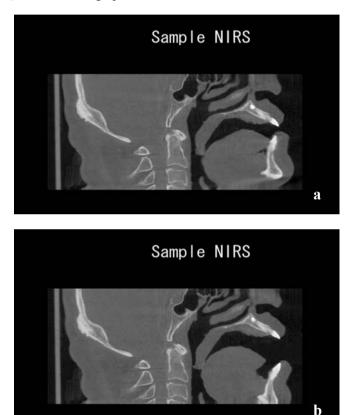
Central sagittal cross sectional CT slices from 256 row 4D-CT, a: start, closed mouth, b: end, mouth opened
